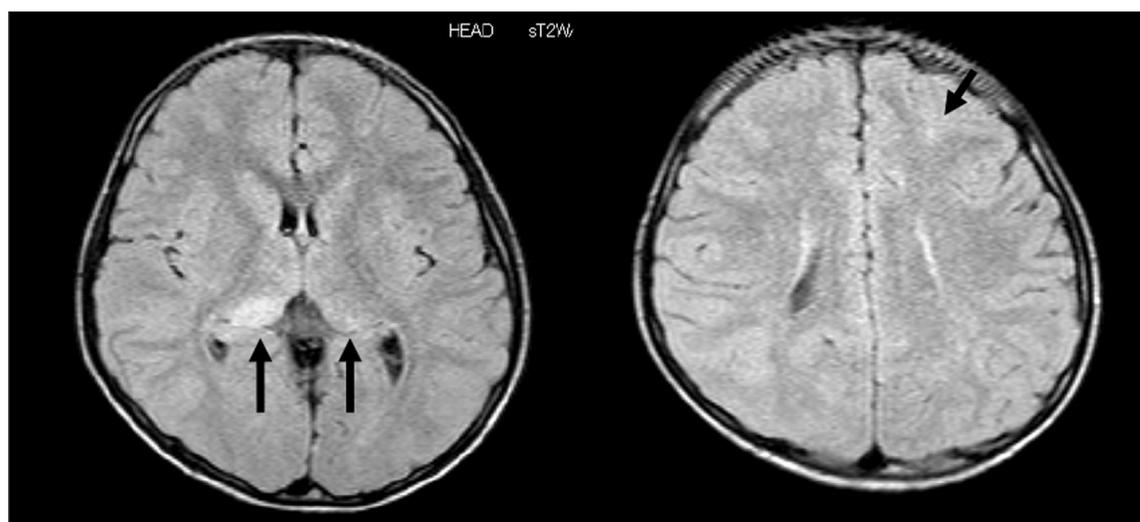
Magnetic resonance imaging findings for the presented case. A fluid-attenuated inverse recovery image showing asymmetrical bilateral lesions of thalami and single small lesion in the juxtacortical white matter of the left frontal lobe (arrows).
